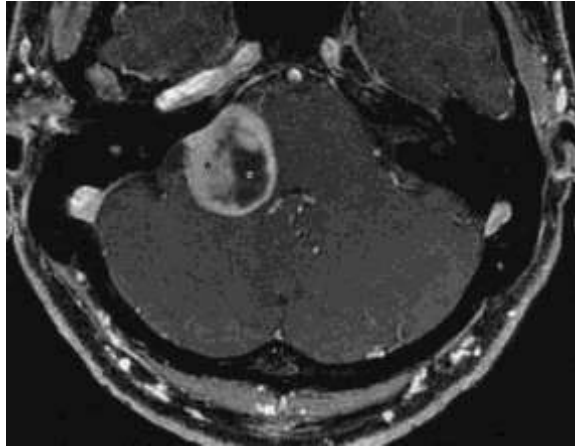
Glioblastoma; axial contrast-enhanced T1-weighted turbo spin echo sequence with fat saturation demonstrating a mostly solid and enhancing lesion (black asterisk) with some cystic / necrotic components (white asterisk) occupying the right CPA. In such a challenging case is not easy to understand the intra-axial exophytic nature of the tumor.
